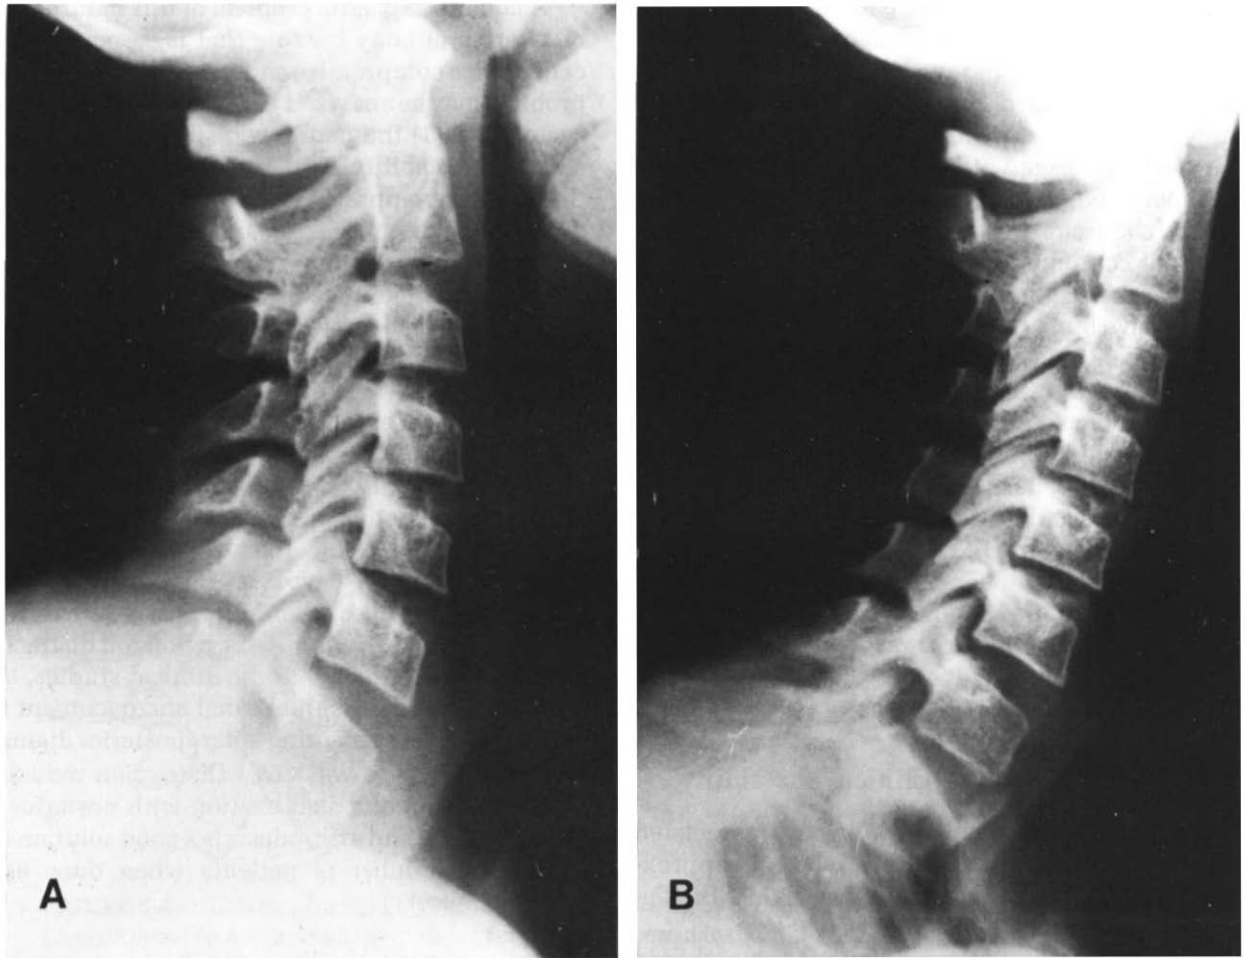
(A) A routine lateral cervical spine radiograph with a good view of C7 seems normal. However, the patient complained of back pain. (B) A radiograph taken with the shoulders pulled down. The fracture of the first thoracic vertebra is now obvious. These radiographs emphasize the necessity of careful and thorough examination of the cervical thoracic junction in any case of persistent undiagnosed neck or back problem following trauma to the spine. The fracture went undiagnosed for 3 months.
